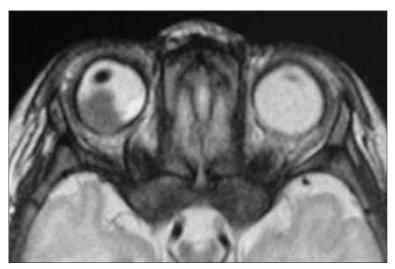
T2-Weighted Magnetic Resonance Image of Eyes and Orbits in Child With Unilateral Retinoblastoma of Right Eye Demonstrating a Lesion That Is Hypointense to the Vitreous on T2 Imaging.
